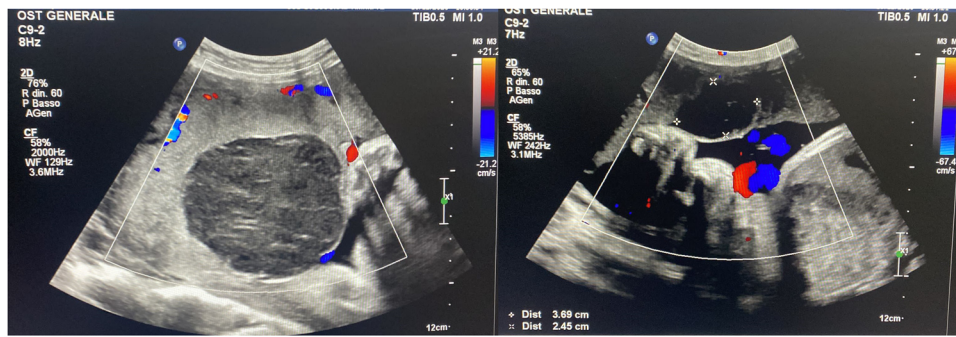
Ultrasound scan performed at 35 weeks + 4 days of gestational age, showing the original infarcted chorioangioma and the newly developed chorioangioma with signs of infarction
